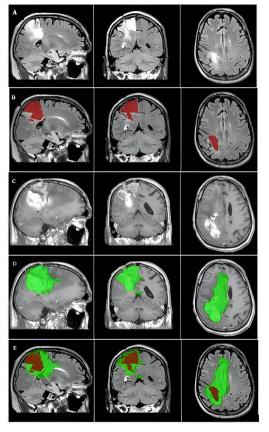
case 2. Tumor Recurrence and FLAIR Overlap. Allimages are in MNI152 1mm space. -Higher specificity than sensitivity observed -Tumor recurrence mask larger than original tumor mass -Undetected regions bv preoperative FLAIR were infiltrated by cancer cells -Led to rapid tumor progression and poor overall survival
